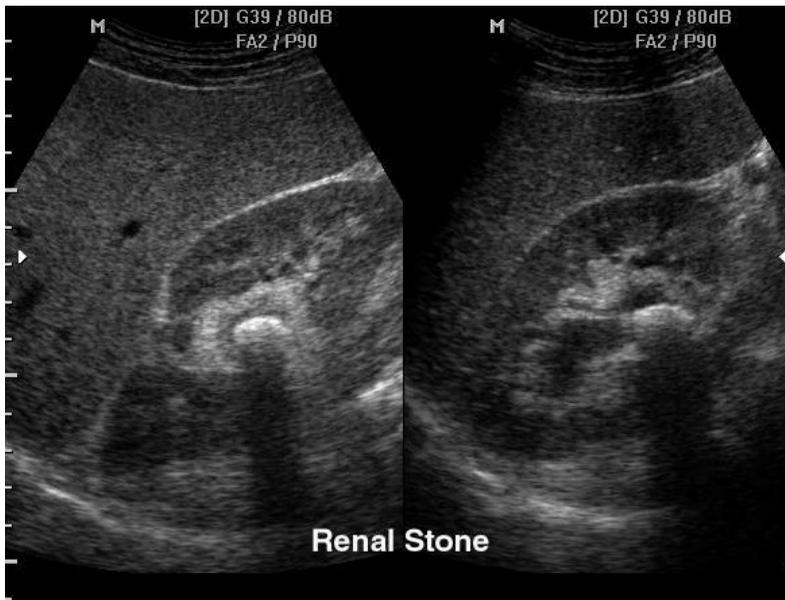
Renal ultrasonography, renal stone
